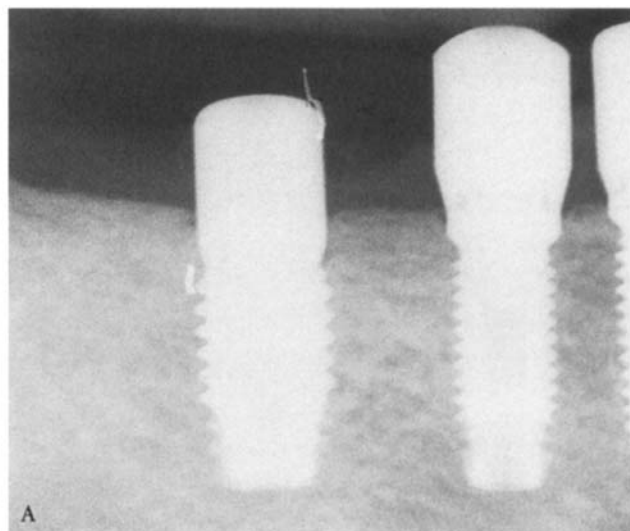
A, Peroperative view of two 5-mm diameter implants replacing missing molars in the maxilla. B, Radiograph taken 4 years post loading. A 5 × 8 and 5 × 10 mm RP fixture replaced missing maxillary molars.
